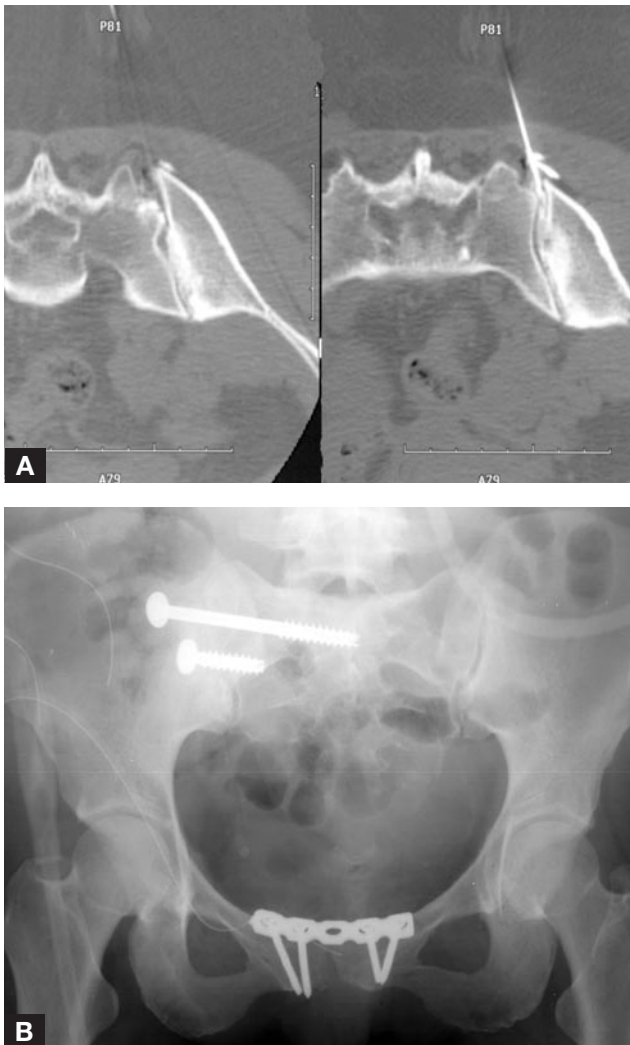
(A) Thirty-eight-year-old patient with chronic symphyseal and posterior pelvic pain 9 years after delivery. Although plain radiographs show no significant pathology, magnetic resonance imaging reveals significant degenerative joint disease. Computed-tomography-guided injection into sacroiliac joint provided temporary pain relief. (B) Symphyseal fusion and formal sacroiliac fusion with placement of 2 screws through anterior approach.
